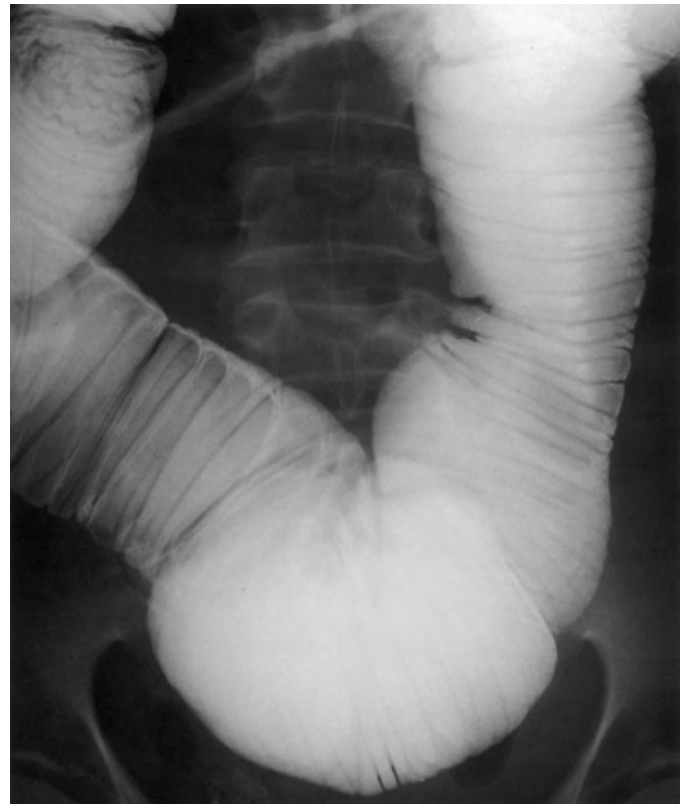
Scleroderma. This spot radiograph from enteroclysis shows a massively dilated small bowel. (Compare the diameter of the lumen with the size of a lumbar vertebral body.) There is also an increased number of folds per inch, producing the hidebound sign.
